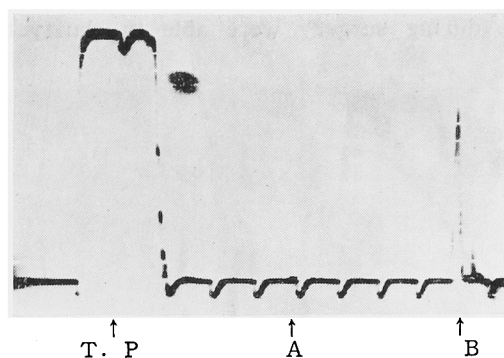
Ultrasono-echogram of Stone (E) Hanging in Water.
